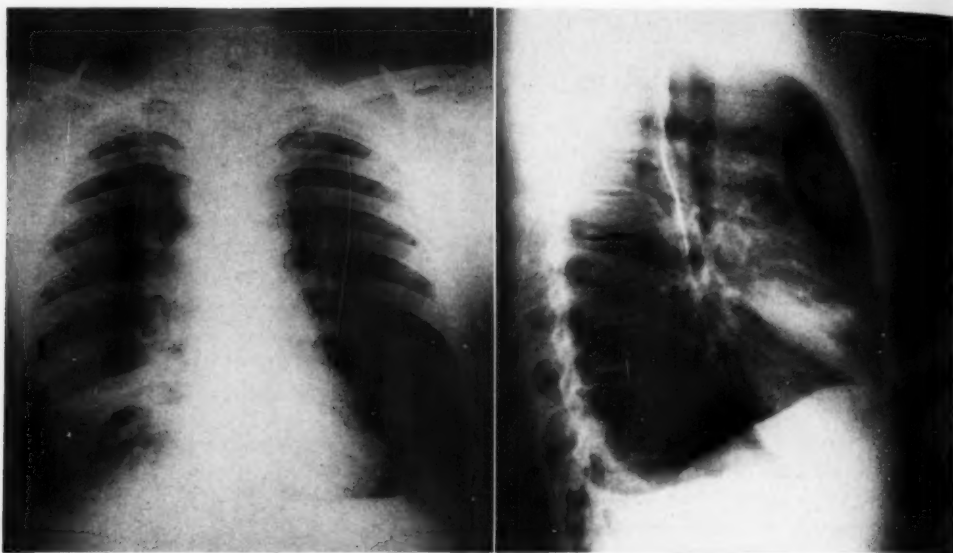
Admission chest roentgenograms of a patient with multiple venous thrombosis, found at autopsy to have a carcinoma of the left upper lobe of the lung. Note the widening of the upper mediastinum on the right, with a density extending downward, laterally, and forward. The nature of this density, which shifted in position (Fig. 3A), was never explained even at autopsy. It may have been due to atelectasis.
